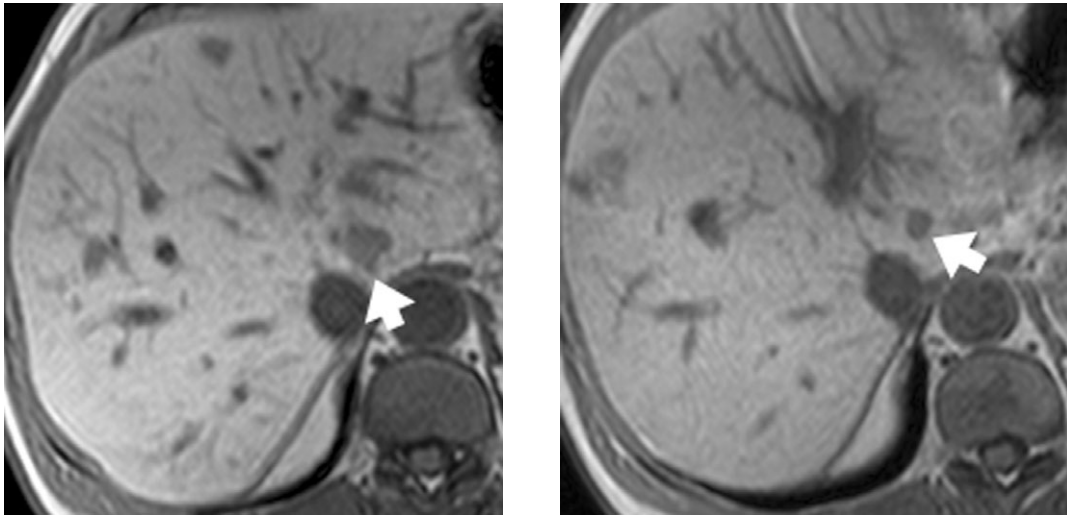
Neo-adjuvant chemotherapy with tumour regression. Pre-chemotherapy (left) and post-chemotherapy (right) T1-weighted MRI obtained at 20 min after the administration of MnDPDP contrast medium. Prior to neoadjuvant treatment, note the 2 cm hypointense metastasis (arrow) lying in close proximity to the intrahepatic inferior vena cava. Treatment with neoadjuvant chemotherapy resulted in downsizing of the metastasis to 1 cm in size with regression of tumour away from the inferior vena cava, thus facilitating surgical clearance.
